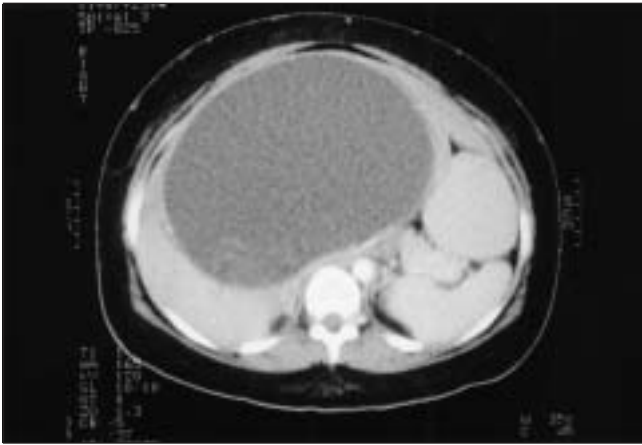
Computed tomography scan showing a large, well circumscribed, low density, 26 cm mass arising from the medial segment of the left lobe of the liver. There was considerable dense debris within the dependent portion of this mass. The mass produced mild dilation of the left intrahepatic biliary radicles
